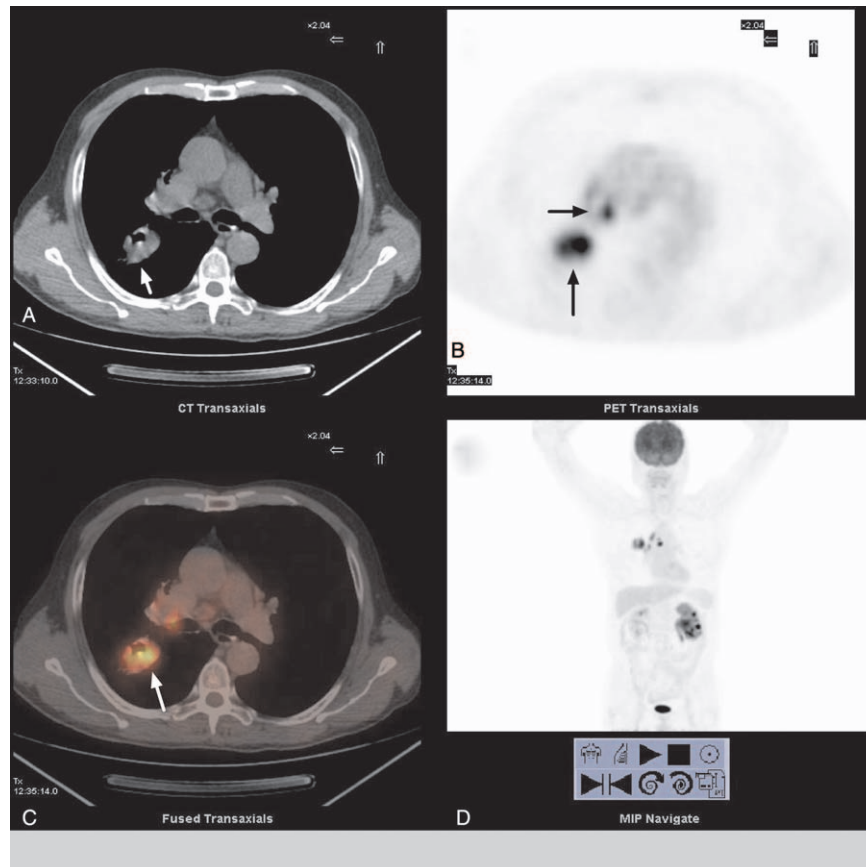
PET/CT scan showed a 45 mm \times 25 mm mass, high-density shadow, behaving as a cavity and burrs with high uptake in the right lung (SUVmax10.6) (arrows). Multiple enlarged lymph nodes could be seen in the right pulmonary hilum and mediastinum with high uptake (SUVmax11.6) (arrows) (shown in A, B, C, and D).
